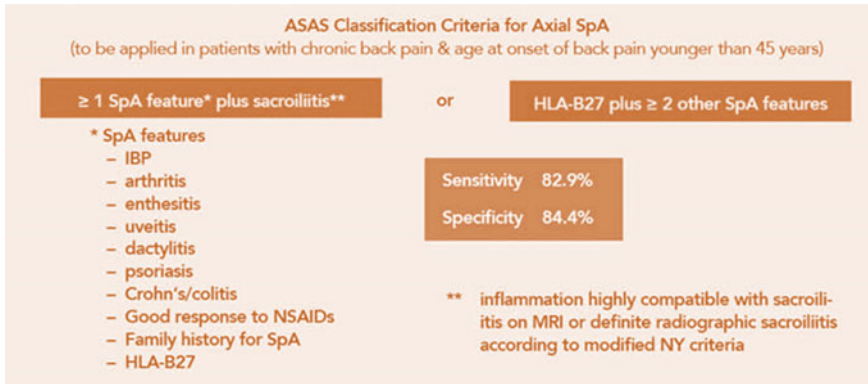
ASAS classification criteria for axSpA. *ASAS* Assessment of SpondyloArthritis International Society, *axSpA* axial spondyloarthritis, *HLA-B27* Human leukocyte antigen B27, *IBP* inflammatory back pain, *MRI* magnetic resonance imaging, *NSAID* non-steroidal anti-inflammatory drug, *NY* New York, *SpA* spondyloarthritis
